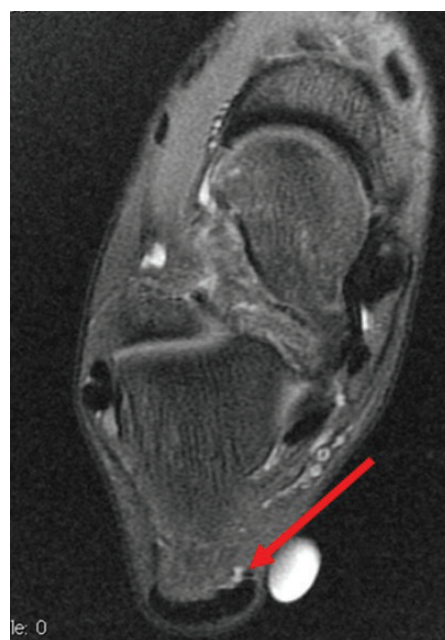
Magnetic resonance imaging scan showing a normal appearance of the plantaris tendon (arrow) adjacent to the Achilles tendon.
